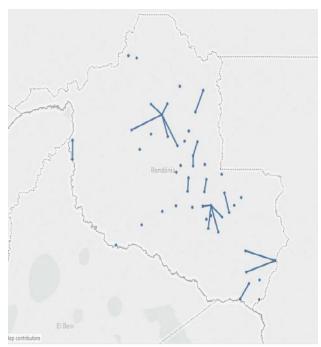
Geographic map of population displacement for X-ray examination in the state of Rondônia-RO.
